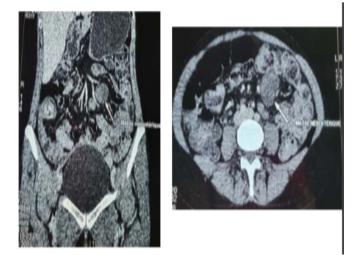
CT images: sagittal and axial views of the mesenteric lesion.
